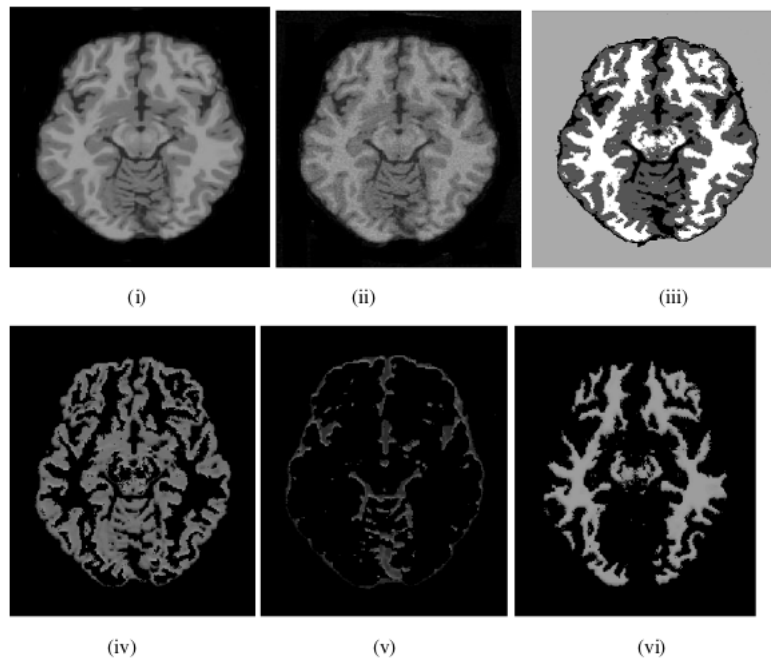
(i) MRI T1-60, (ii) MRI with 3% noise, (iii) MRI segmented using ACO-FCM, (iv) MRI with Gray, (v) CSF, (vi) MRI with White
